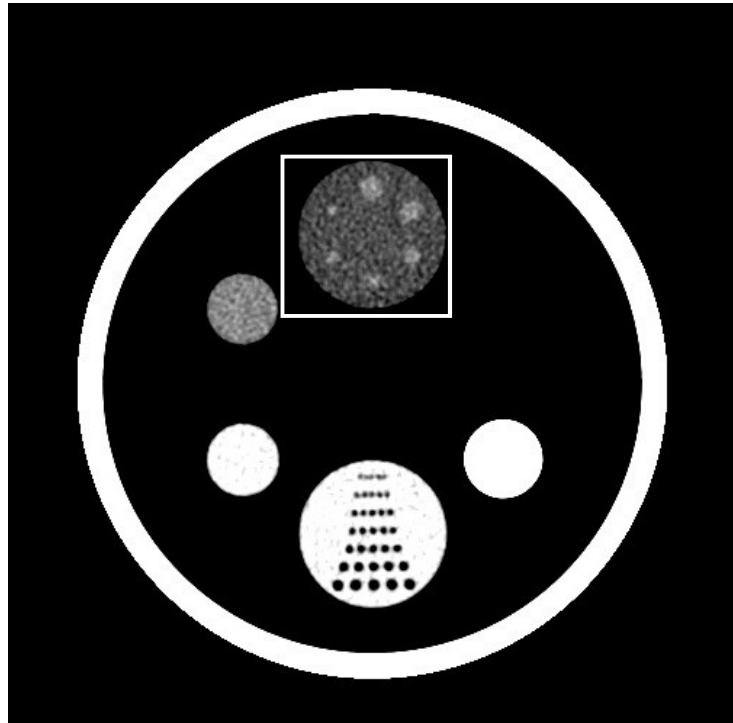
CT low contrast resolution
